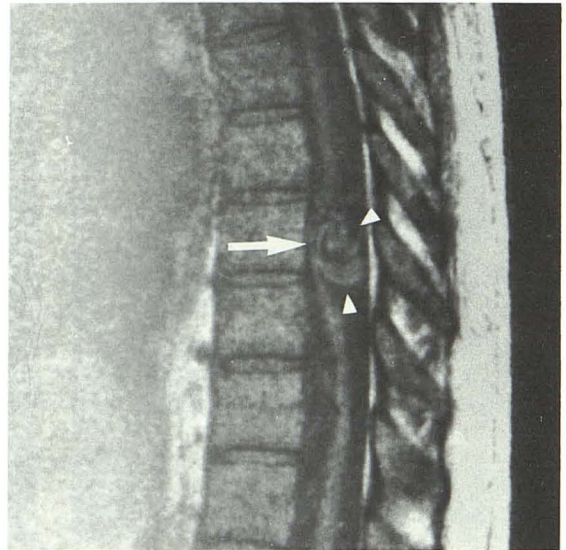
Perimedullary fistula above conus medullaris in a 38-year-old patient. Sagittal T1-weighted (400/28) image. In thoracic area, spinal cord is displaced forward (arrow) by huge abnormal signal structures (arrowheads) corresponding to posterior venous drainage.
